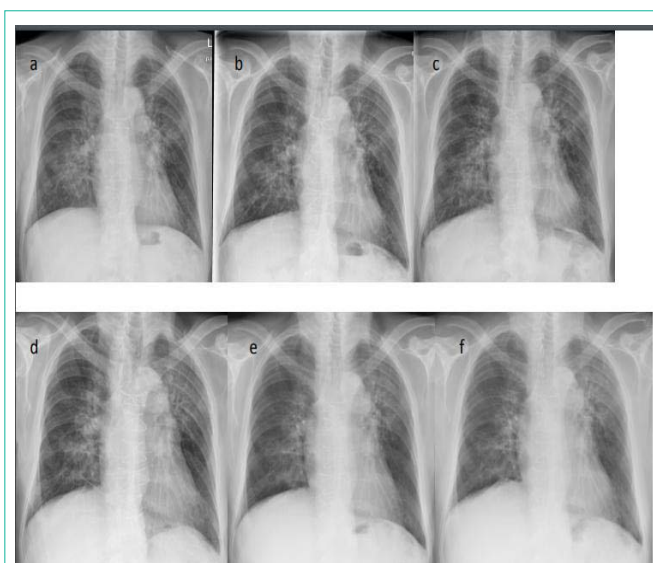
X-ray controls after discontinuation of Imatinib and introduction of immunosuppressive therapy after (a) 1 weeks; (b) 3 weeks; (c) 5 weeks; (d) 8 weeks; (e) 14 weeks; (f) 23 weeks.
